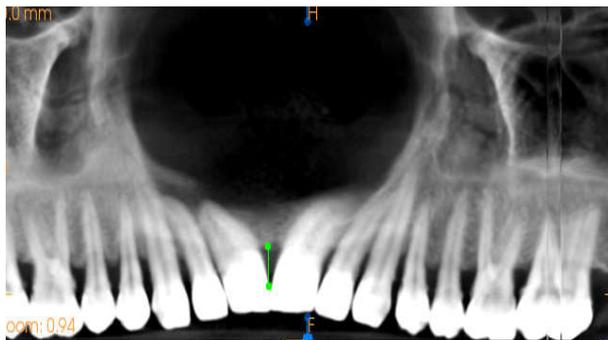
Distance betⁿ CP-AC on CBCT
